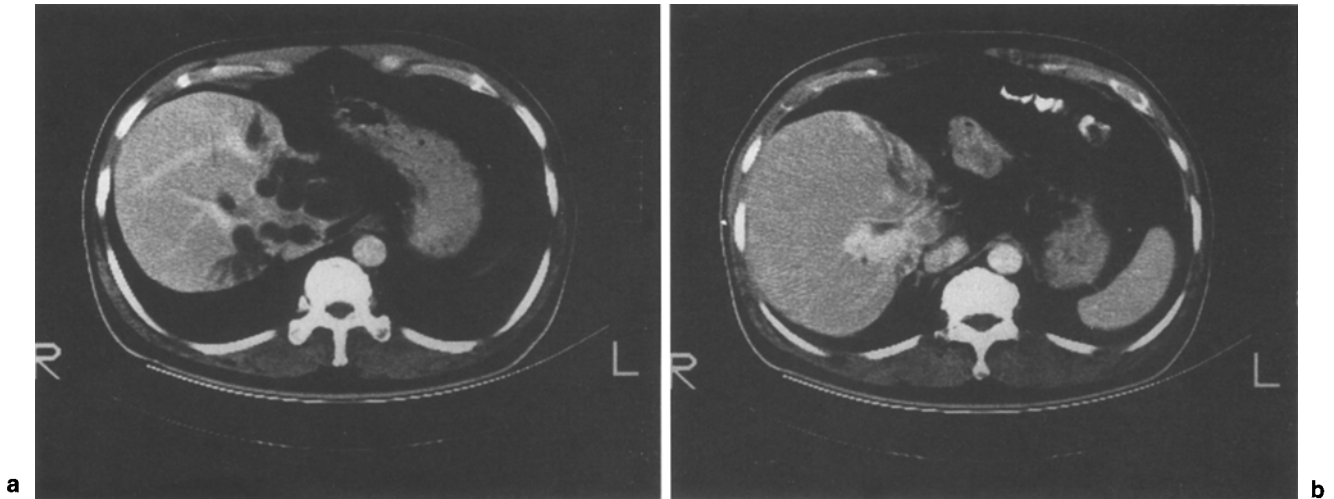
Contrast enhanced computed tomography shows the atrophied left lobe and remarkable dilatation of the intrahepatic ducts. An infiltrative lesion at the porta hepatis
